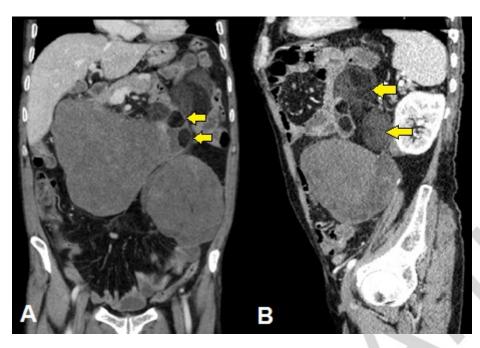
A. Abdominal contrast-enhanced CT in the portal phase, MPR reconstruction and coronal section. A large bilobed intraperitoneal soft tissue mass that displaces the root of the mesentery is seen with a heterogeneous density and hypodense tracts, compatible with a fatty tumor. The arrows indicate two hypodense nodules with more fat, within the duodenum. B. Left parasagittal section: two large hypodense nodules, with a lot of fatty tissue in the anterior pararenal space and retroperitoneum (arrows).
